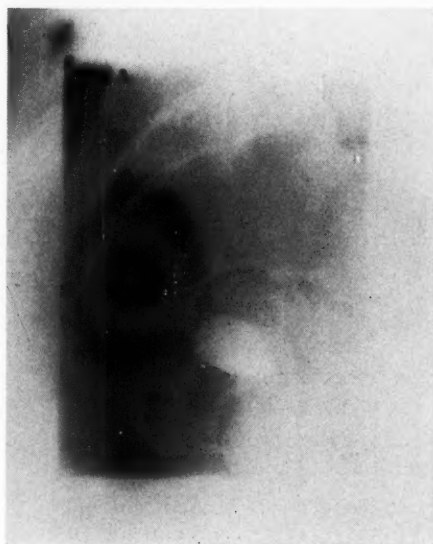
Roentgenogram made on the therapy apparatus in a lateral position. A cotton plug soaked in barium lies in the vaginal vault. All of the lymph nodes are included in the region so irradiated.
